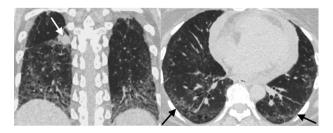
Forty-four-year-old woman with systemic sclerosis-associated interstitial lung disease and an enlarging right lower lobe solid nodule corresponding to a biopsy proven non-small cell lung cancer. Left. Coronal CT image demonstrates the lung cancer (arrow) and lower lung predominant fibrosis marked by volume loss, ground-glass opacities, and traction bronchiectasis. Right. Axial CT image of the lung bases demonstrates peripheral predominant ground glass, reticular markings, and traction bronchiectasis (arrows) most consistent with a non-specific interstitial pneumonitis pattern.
